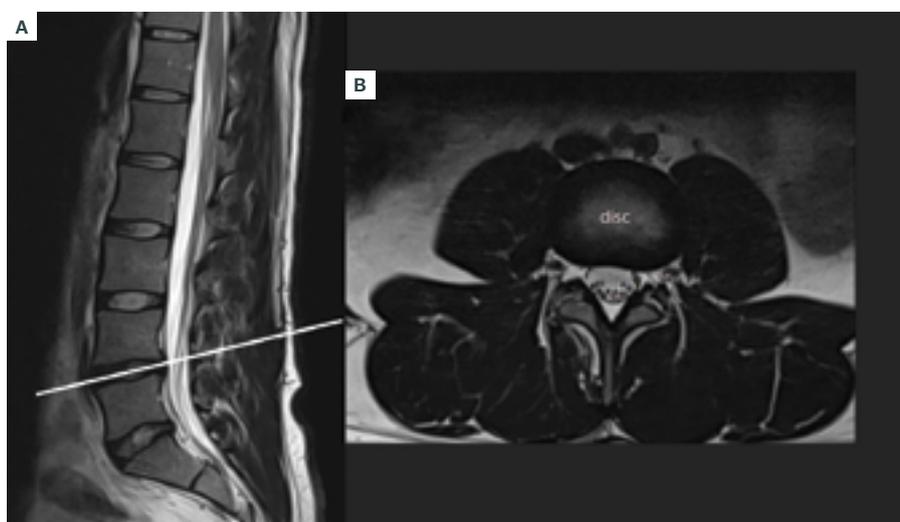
T2 weighted magnetic resonance imaging scan of the lumbar-sacral spine. (A) Mid-sagittal section. (B) Axial section at level of the L4/5 disc space with intrathecal location of nerve roots labelled.
